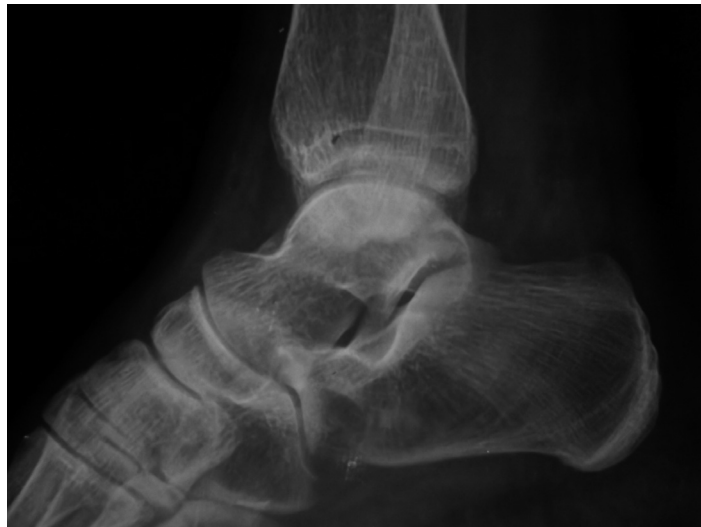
Left lateral radiographs were unremarkable
